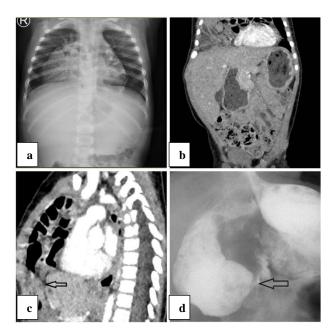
(a) Chest X-ray, diaphragmatic hernia; (b) CT scan showing right hemidiaphragm defect with bowel herniated through it into the right hemithorax, displacing heart and mediastinal structures to the left side, causing mass-effect on the pyloric canal and proximal duodenum; (c) component within the dilated second part of the duodenum; (d) showing duodenal obstruction suggestive of web.
